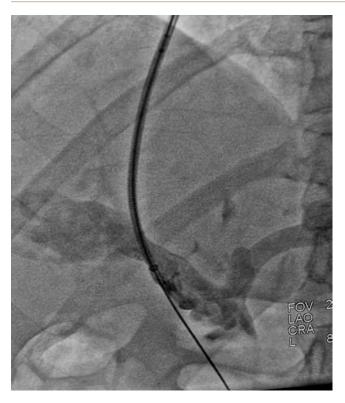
Patient E. Intraoperative X-ray image. Catheterization by an introducer and right hepatic vein angiography
